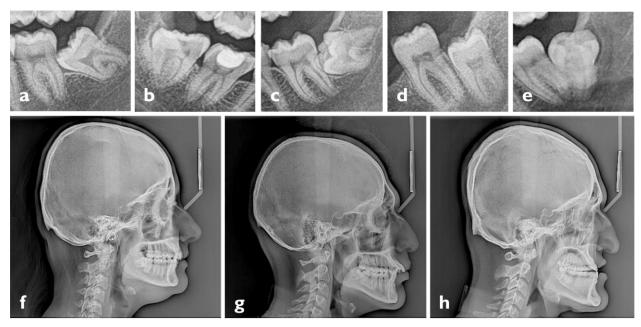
Cropped digital panoramic radiographic showing examples of Winter's classification. (a) mesioangular, (b) distoangular (c) horizontal (d) vertical (e) any other. Figure f-h showing facial skeletal types. (f) class I, (g) class II and (h) class III
